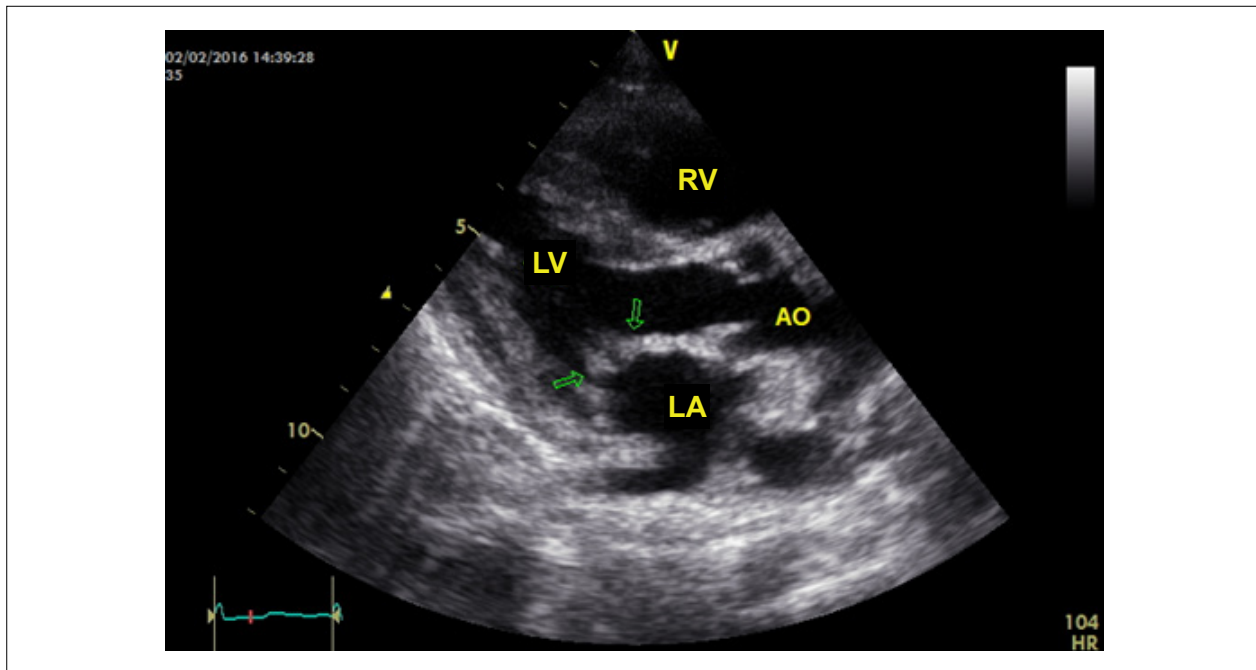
Mitral valve thickening in longitudinal parasternal section after six months of enzyme replacement therapy. RV: right ventricle; LV: left ventricle; AO: aorta; LA: left atrium.
